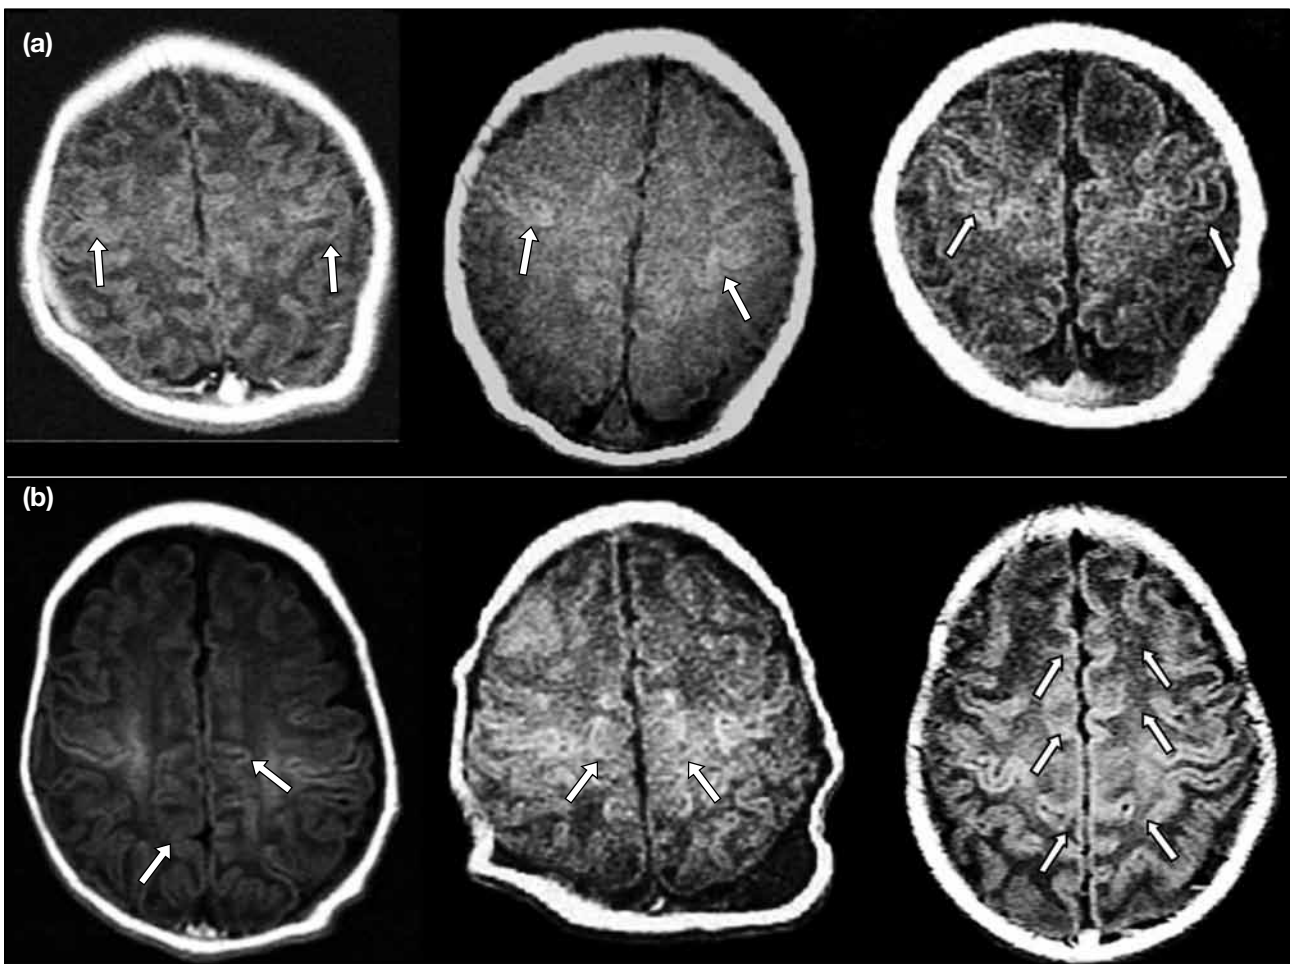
Spin-echo T1-weighted magnetic resonance imaging showing normal signal, mild signal abnormality, and moderate signal abnormality (arrows) of the (a) central fissure and (b) interhemispheric fissure.
